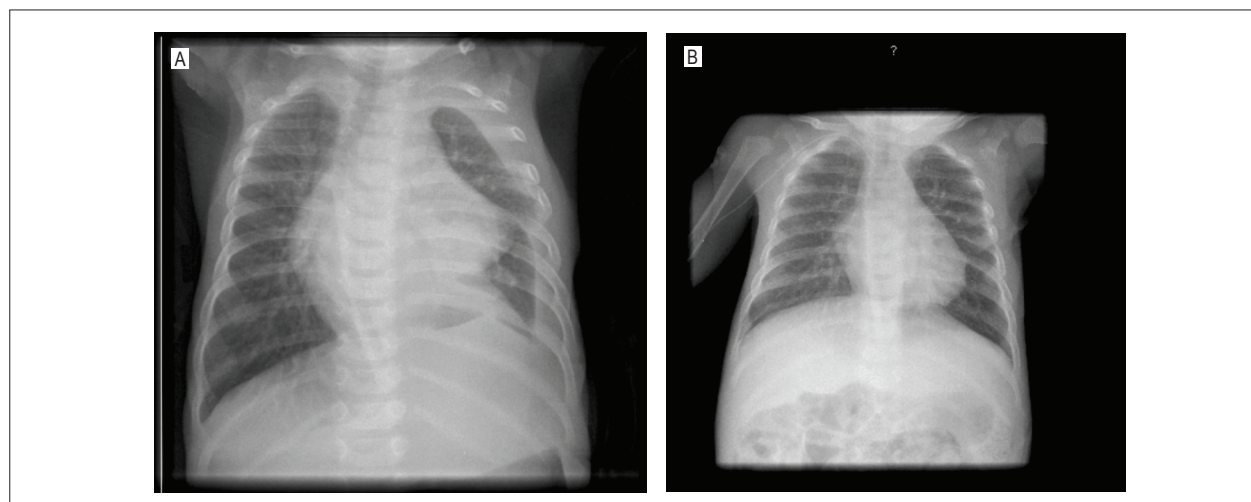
A: Chest X-ray of J.M.U.S. on July 12, 2008. B: Chest X-ray of J.M.U.S. on August 25, 2008.
